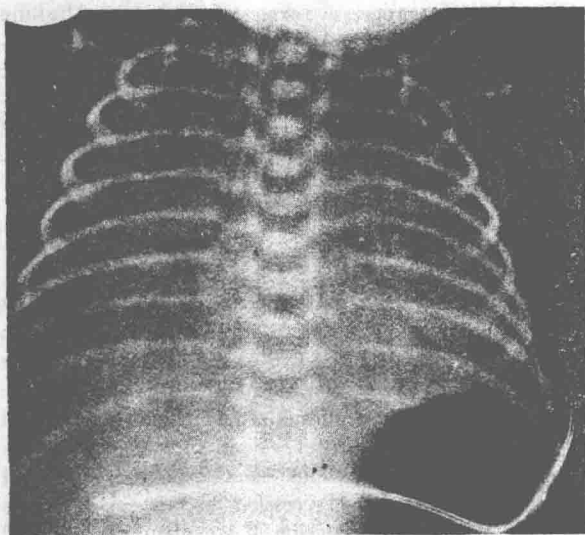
Chest radiograph of an infant with hyaline membrane disease. Note the diffuse fine reticulogranular pattern and the air bronchogram.
